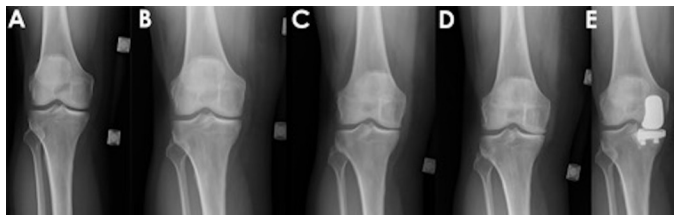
(A–E) Right knee plain radiographs' sequence demonstrating the natural history of a medial compartment with an unrepaired posterior medial meniscal root tear over a period of 12 months with progressive medial compartment joint space narrowing and ultimately a conversion to a medial compartment hemiarthroplasty.
